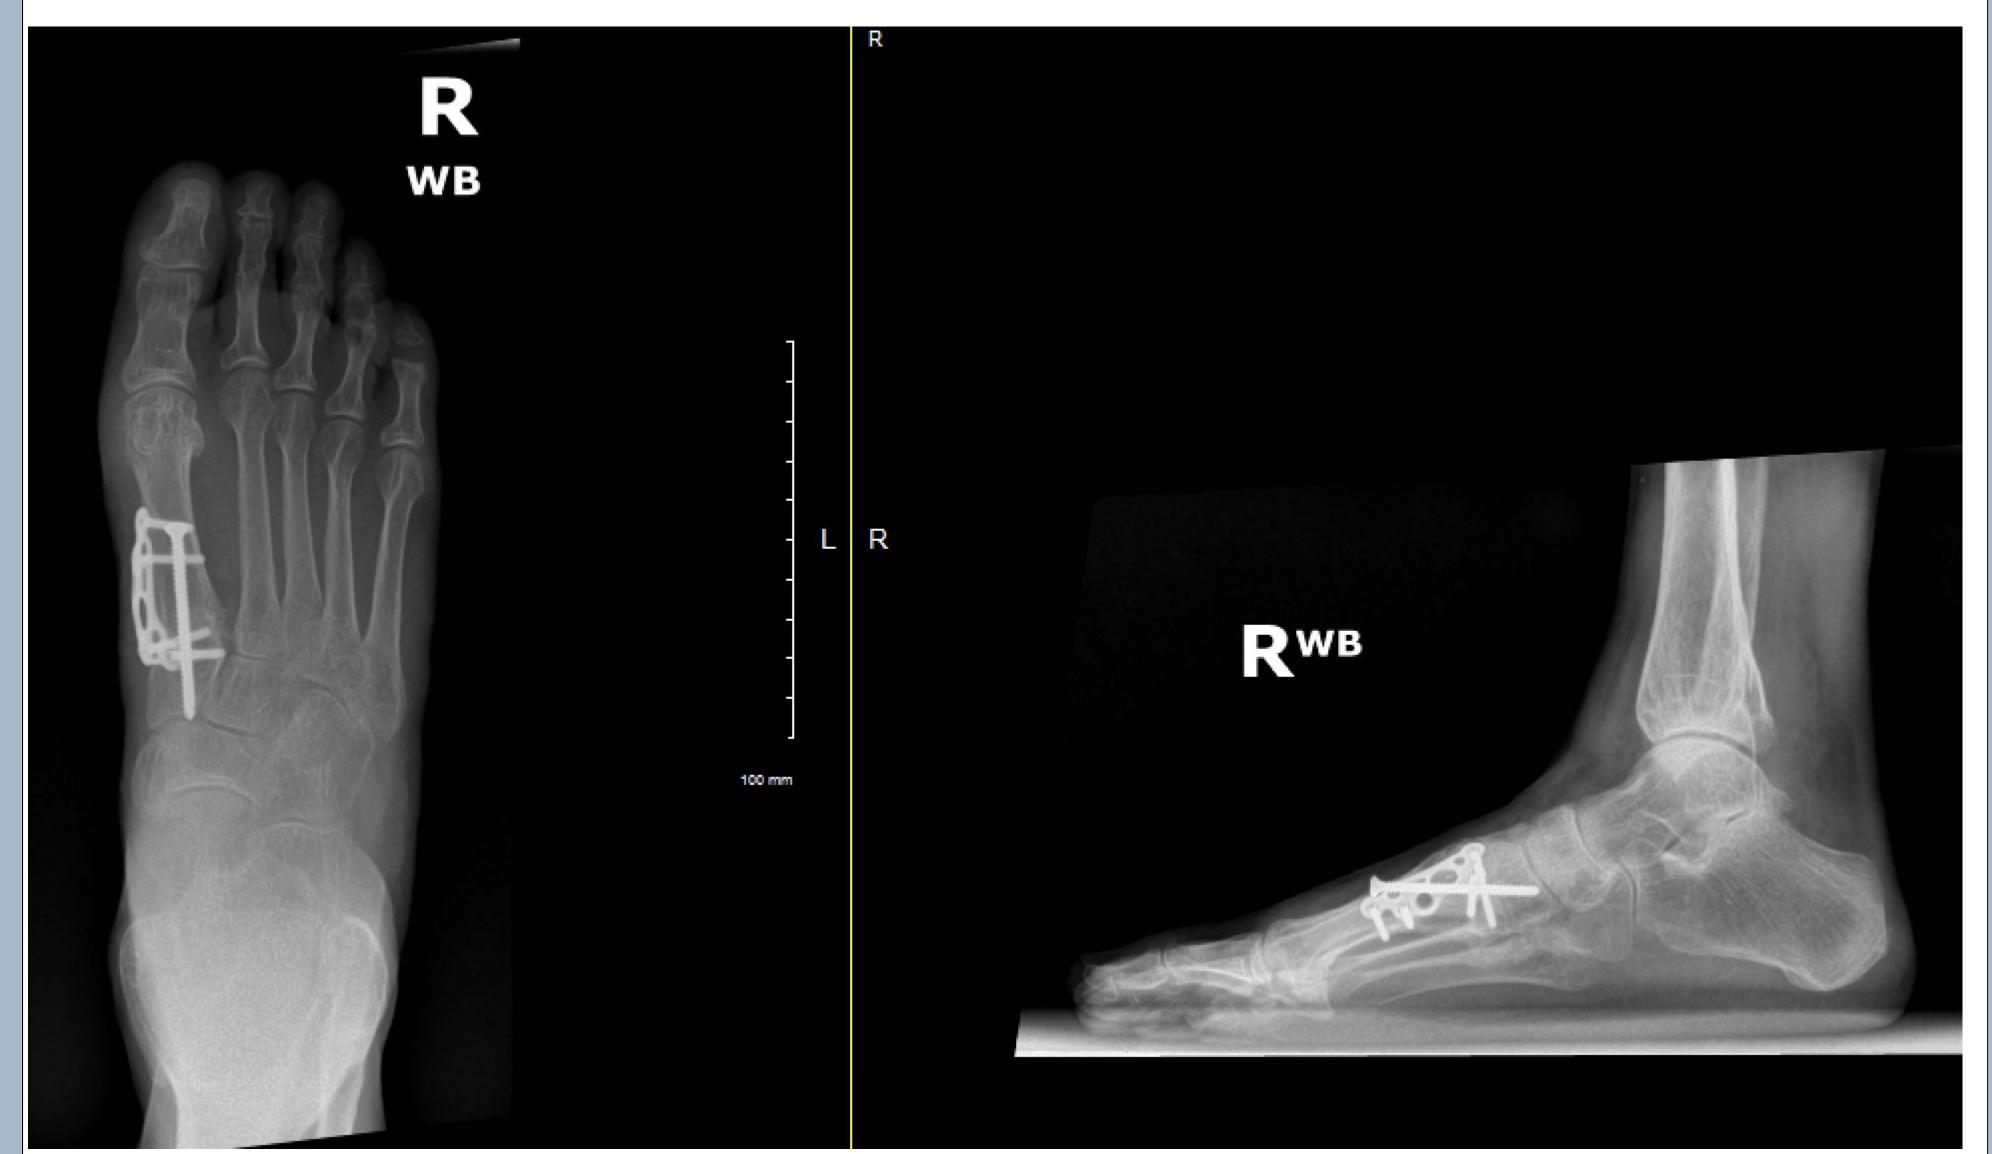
Post-operatively hallux IPJ contracture resolved on radiographs. This is evident particularly on lateral view.
